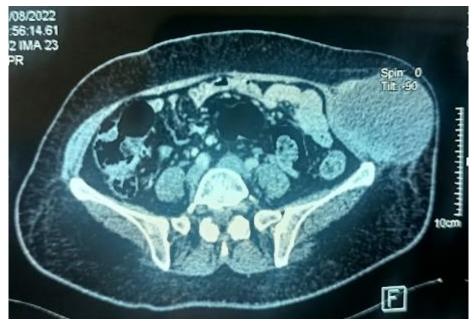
Abdominal CT showing a well-circumscribed homogeneously contrast-enhancing mass on the left anterolateral abdominal wall
